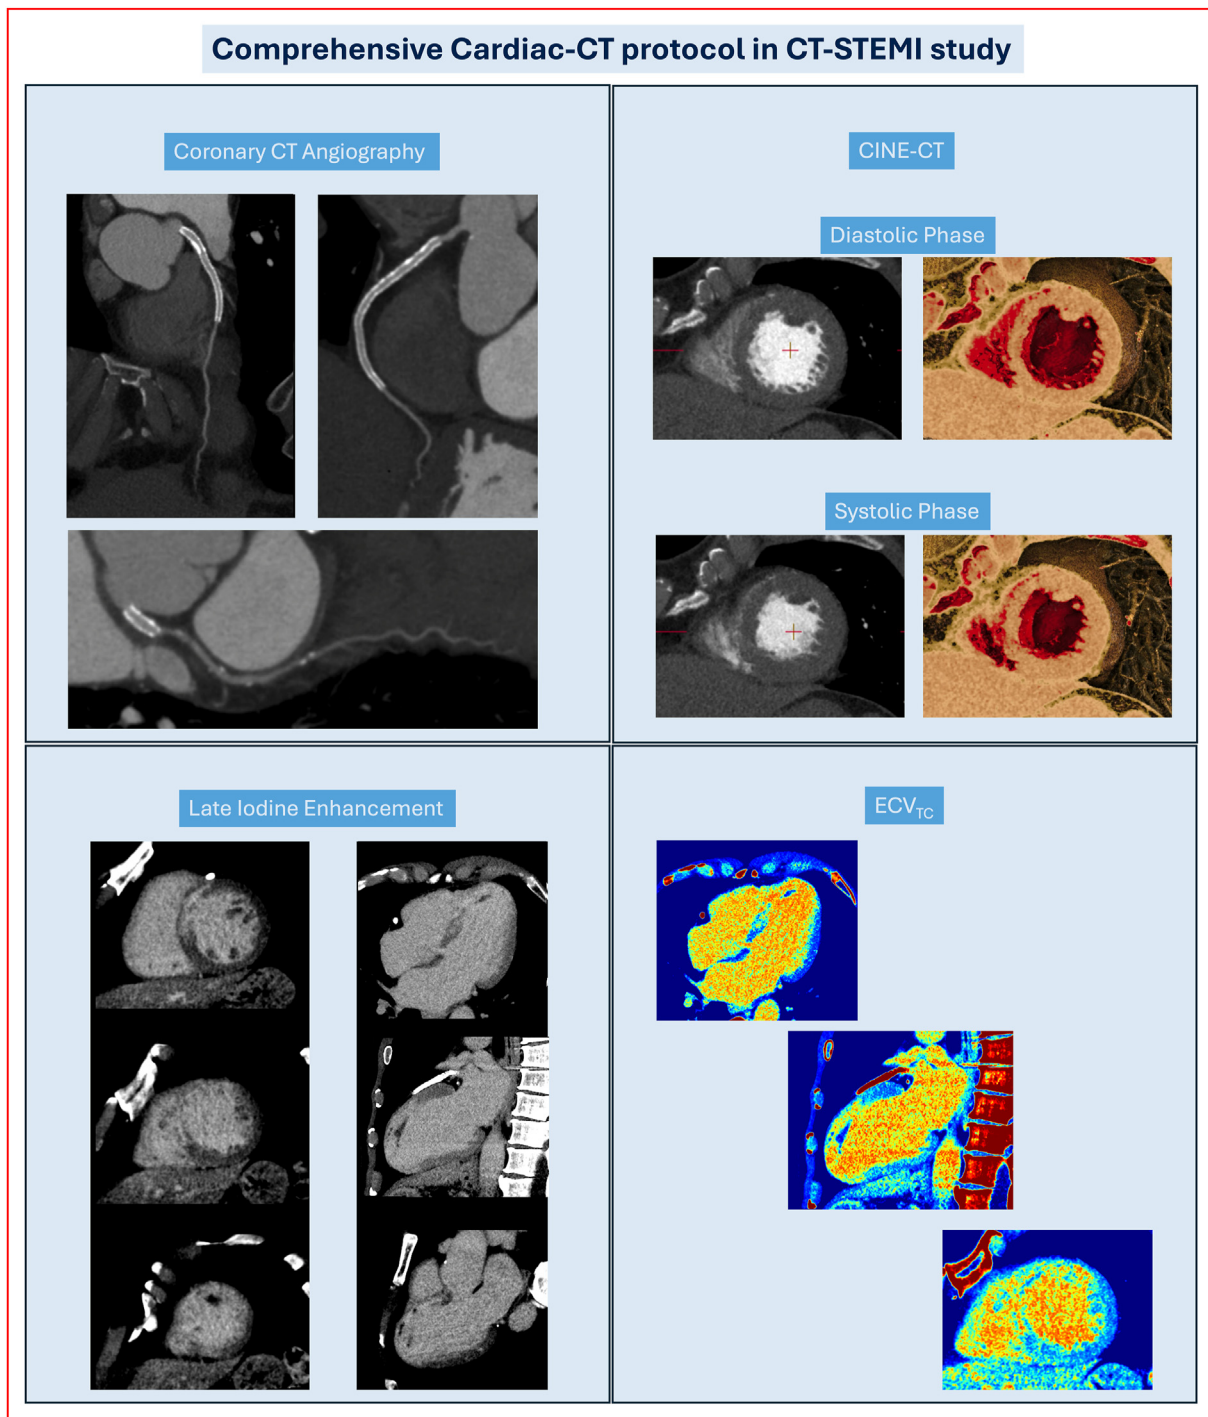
CCT protocol in CT-STEMI study.
